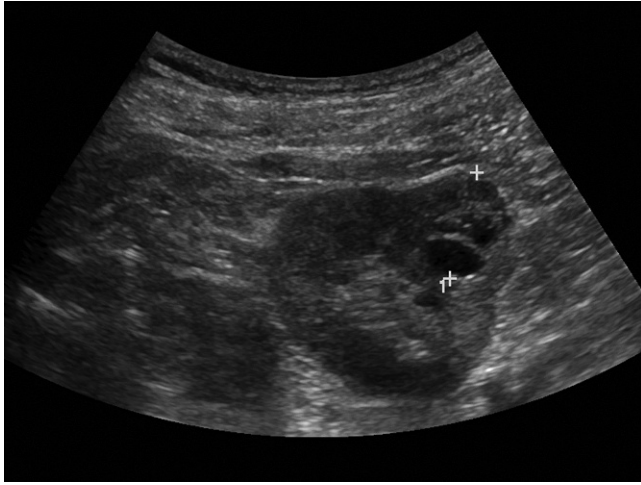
Real time ultrasound exam of the left kidney demonstrates a multi-septated mass with cystic and solid components noted within the left kidney
